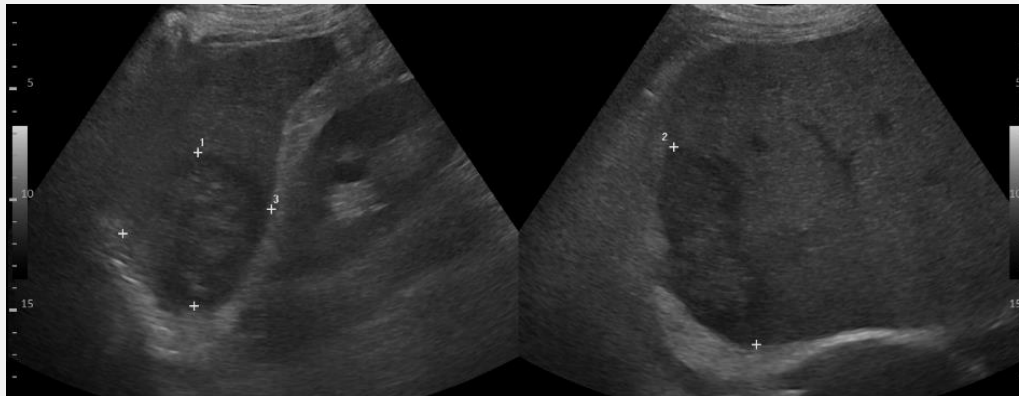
Ultrasound images of the right liver showing a hypoechoic solid 7 x 10 x 7 cm right liver lesion. No colour doppler signal within to indicate increased intralesional vascularity (not shown). Background diffusely increased parenchymal echogenicity. No intrahepatic biliary duct dilatation. Several gallstones in the gallbladder body but no evidence of cholecystitis (not shown).
